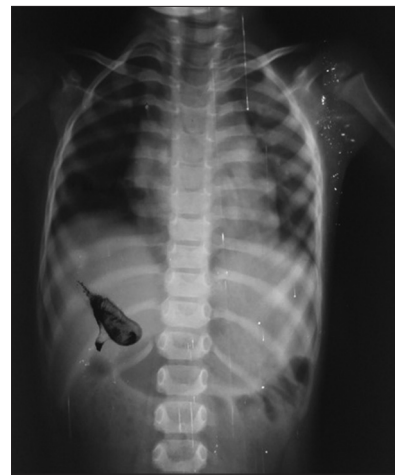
X-ray chest AP view showing hyperinflation of right lung field indicating right lung field
